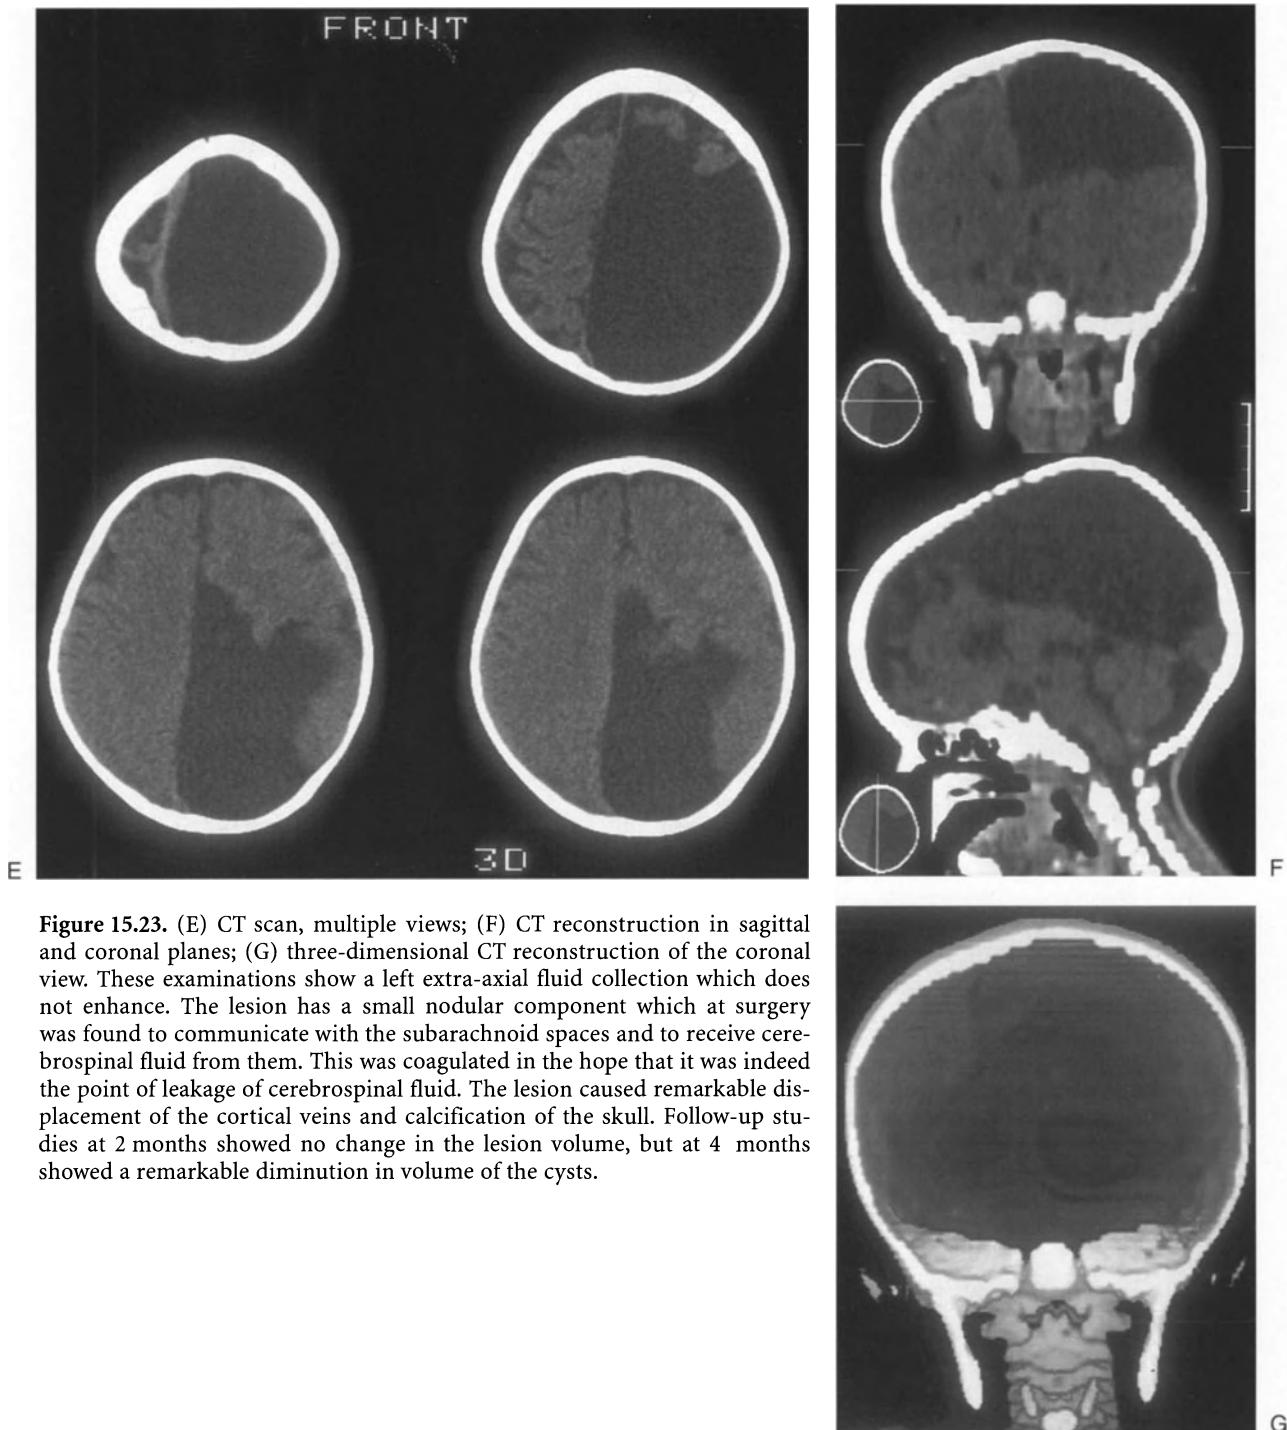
(E) CT scan, multiple views; (F) CT reconstruction in sagittal and coronal planes; (G) three-dimensional CT reconstruction of the coronal view. These examinations show a left extra-axial fluid collection which does not enhance. The lesion has a small nodular component which at surgery was found to communicate with the subarachnoid spaces and to receive cerebrospinal fluid from them. This was coagulated in the hope that it was indeed the point of leakage of cerebrospinal fluid. The lesion caused remarkable displacement of the cortical veins and calcification of the skull. Follow-up studies at 2 months showed no change in the lesion volume, but at 4 months showed a remarkable diminution in volume of the cysts.
